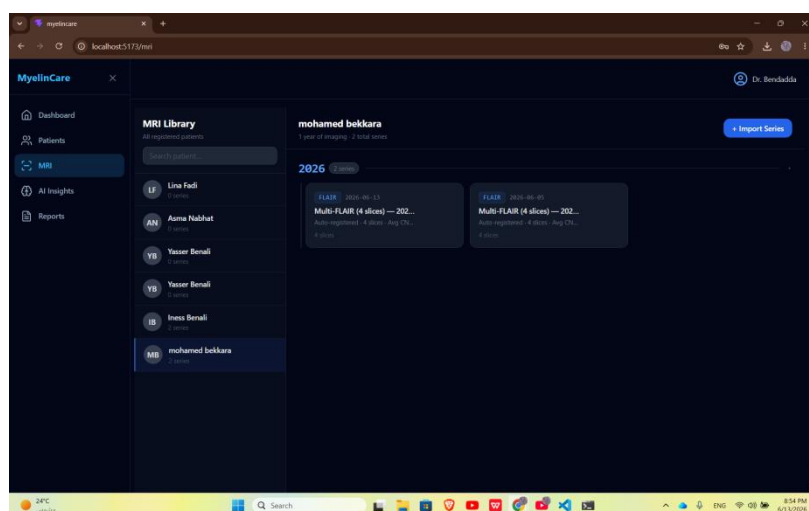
MRI uploads interface.
